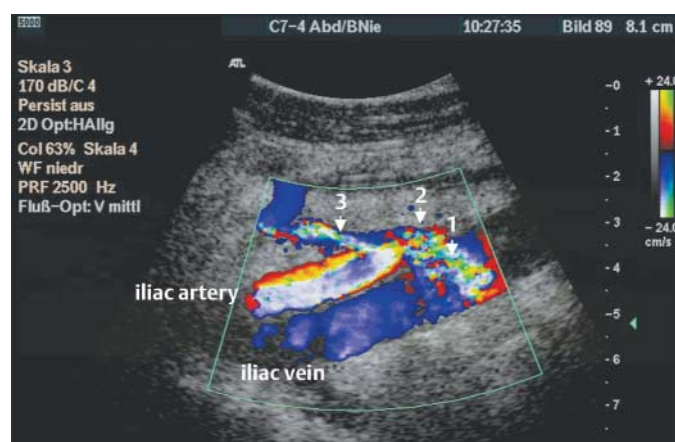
Colour coded duplex sonography of the renal transplant vein: 1 anastomosis, 2 proximal to the anastomosis, 3 middle.
